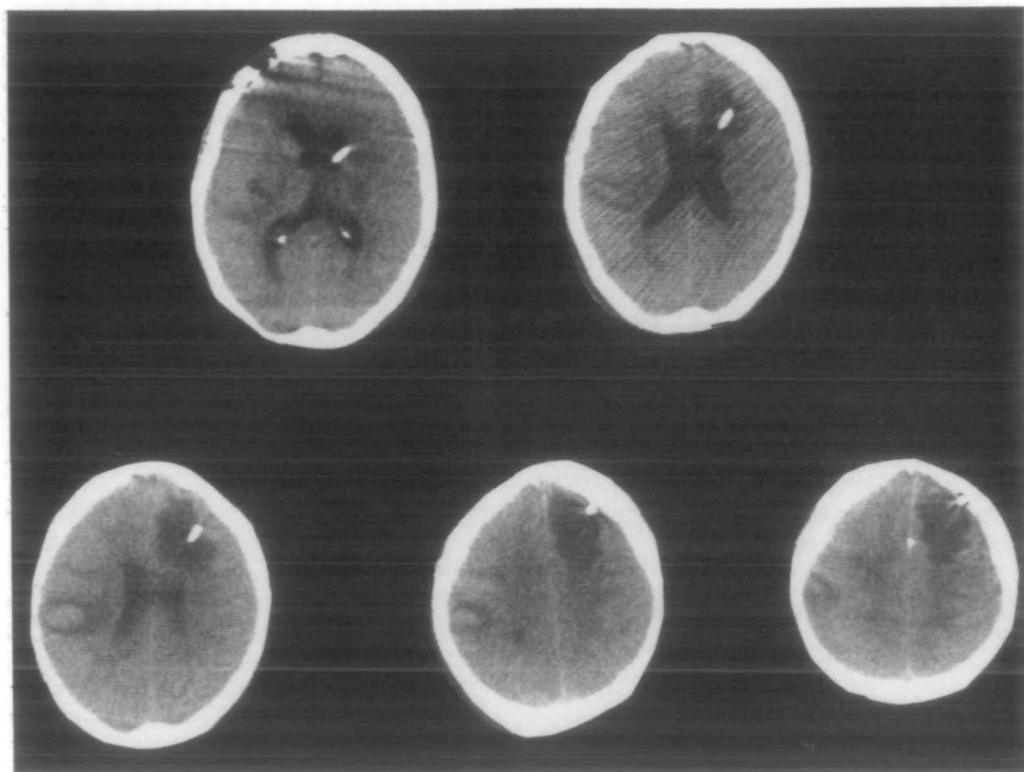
CT scan of Case 2 performed 3 weeks after onset. The structures involved by the lesions are discussed in the text.
